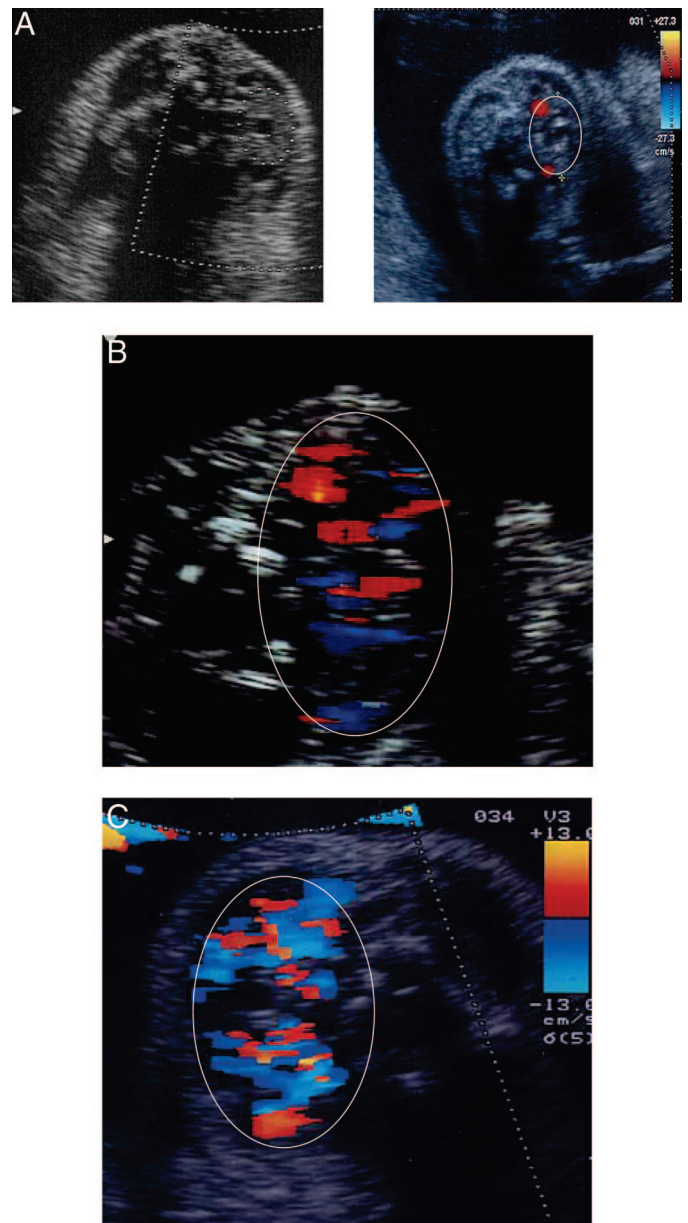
Fetal thyroid and ultrasonography. A, Fetal thyroid gland with normal circumference and increased diameter. Note the central echo-free disc corresponding to the trachea and carotid arteries visualized by color Doppler. B, Fetal goiter and hypothyroidism; peripheral flash on the color Doppler. C, Fetal goiter and hyperthyroidism; central flash on the color Doppler. The measurement of fetal thyroid size has been validated and can be used in routine prenatal care. The color Doppler is still an experimental method that should be validated in more cases.
